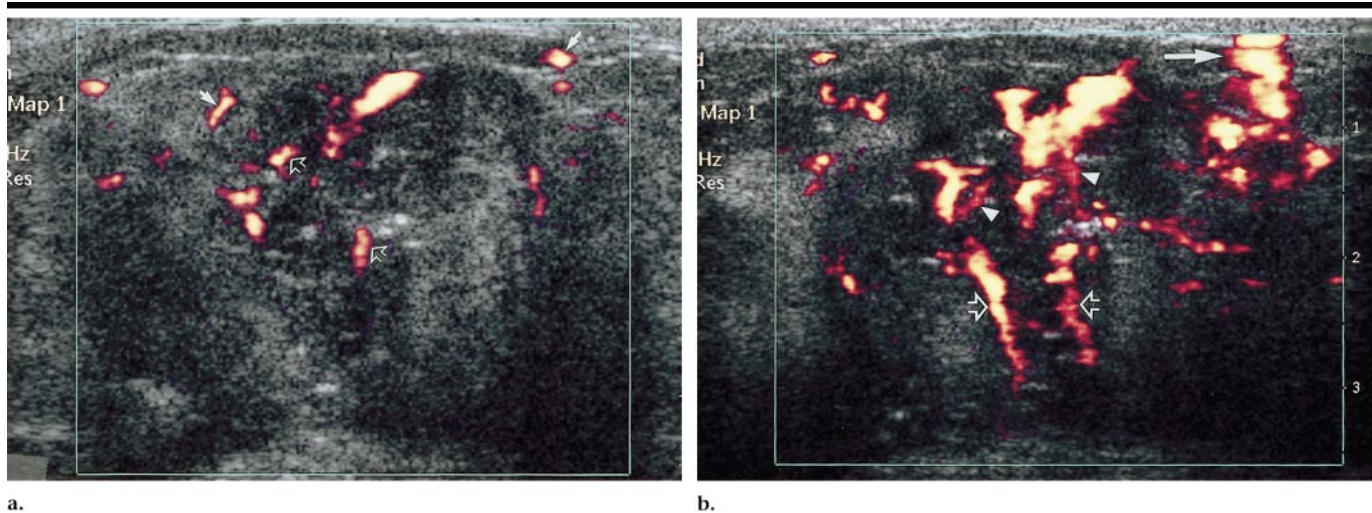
(a) Precontrast radial color power Doppler US image of a primary breast cancer shows central (open arrows) and peripheral (solid arrows) vessels. (b) Postcontrast radial color power Doppler US image of the same lesion as in a shows an increase in central (open arrows), peripheral (solid arrow), and side-branching (arrowheads) vessels.
